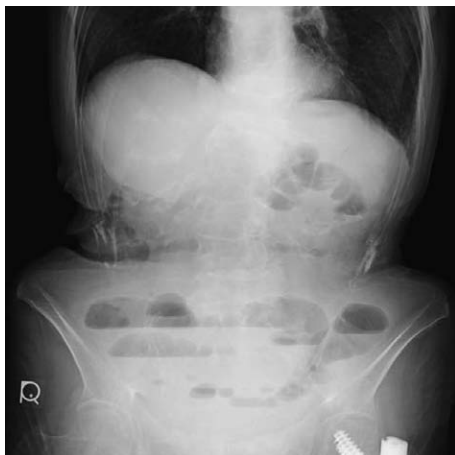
Plain radiograph
